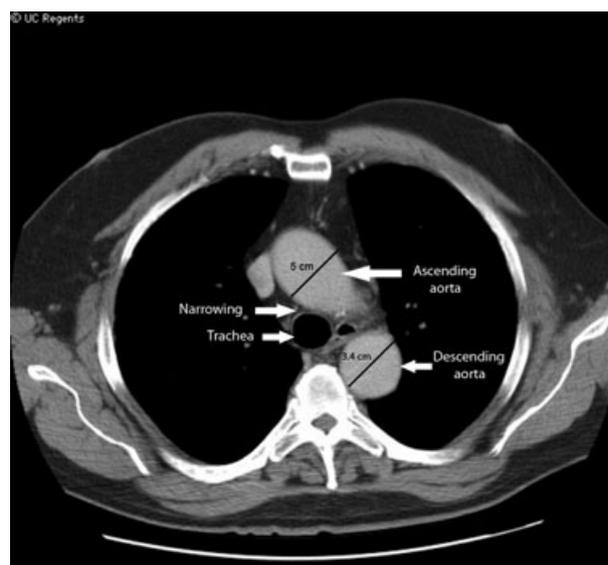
A narrowing of the space between the trachea and the ascending aorta, as well as an aneurysmal dilation of the ascending aorta at 5 cm and descending aorta at 3.4 cm, can be seen in this CT scan.
